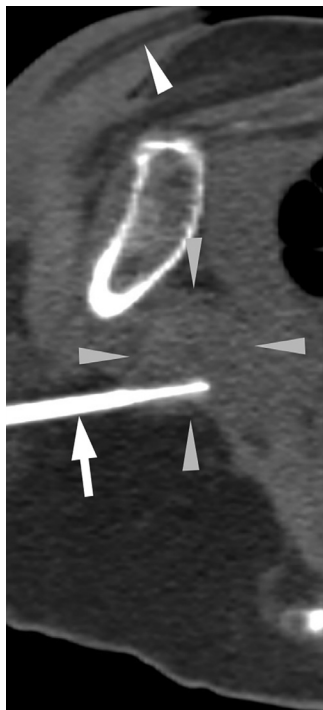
CT sagittal reconstruction image used to confirm the location of the needle tip (white arrow). The gray arrowheads outline the prostate gland, and the white arrowhead indicates a bladder catheter.
